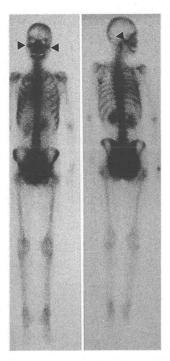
Bone scintigraphy showed uptake in the bilateral TMJ alone (black triangle).
